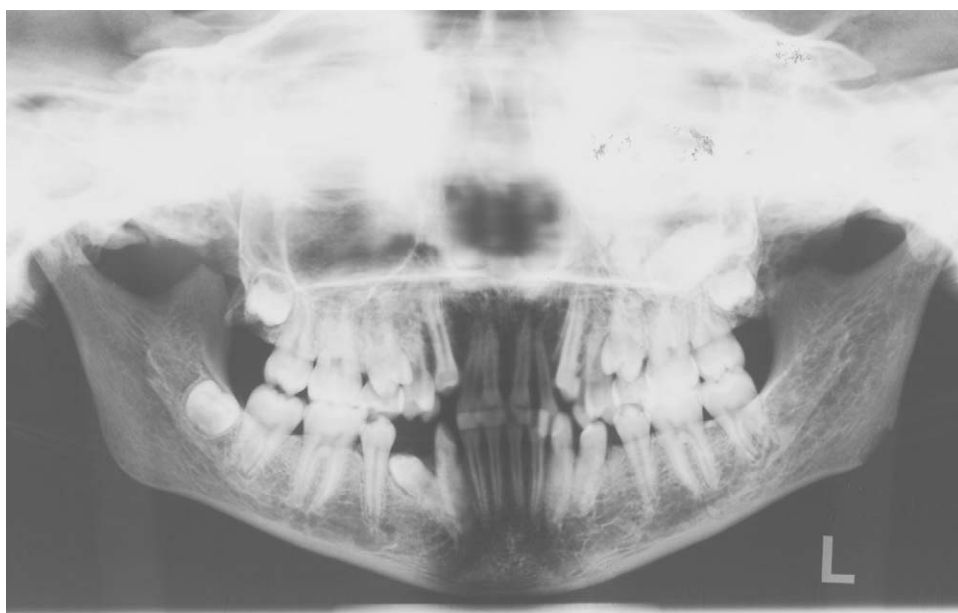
Panoramic radiograph of "Myrtis."
